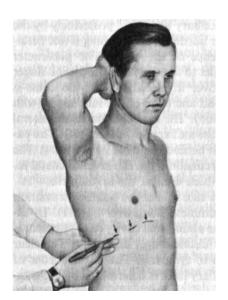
Determining the inferior border of the lung in the right parasternal, midclavicular, and anterior axillary line.
